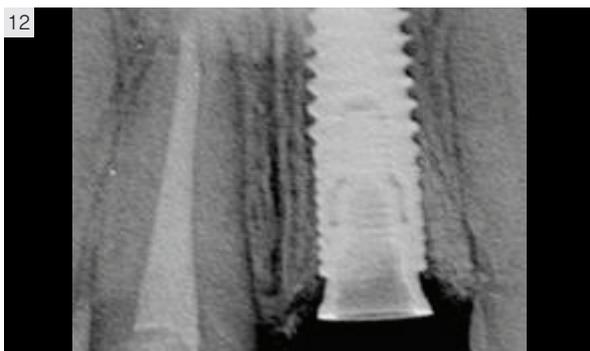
Clinical and radiographic comparison of the MIS single unit (Fig.11) and the MIS CONNECT (Fig.12) abutment.
